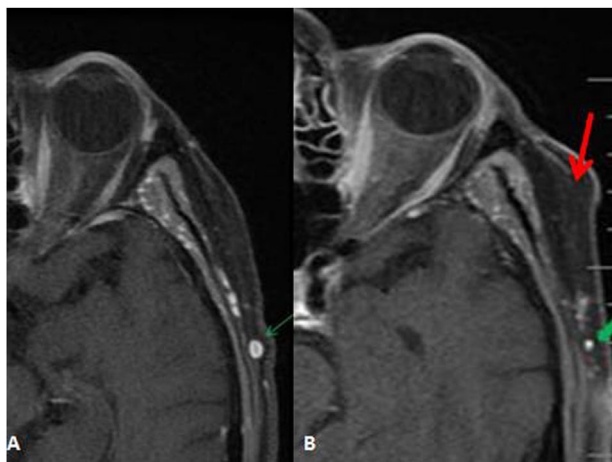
A direct comparison between the T1 precontrast (pre-temporal artery biopsy [pre-TAB]) (A, green arrow) and T1 postcontrast (post-TAB) (B) axial MRI shows the reduction in the lumen of the temporal artery, and there is postoperative change in the surrounding soft tissue (red arrow) around the left TAB site (green arrows). Note the postoperative TAB changes with soft-tissue edema and the resolution of the previously seen mural enhancement differentiating the vessel from a vein.
